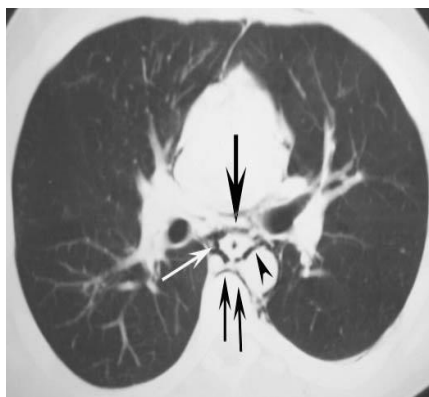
Axial CT scan image showing air surrounding the descending aorta (black arrowhead), azygos vein (white arrow), oesophagus (black arrow), and anterior portion of the spine (two black arrows).^{1,2}
